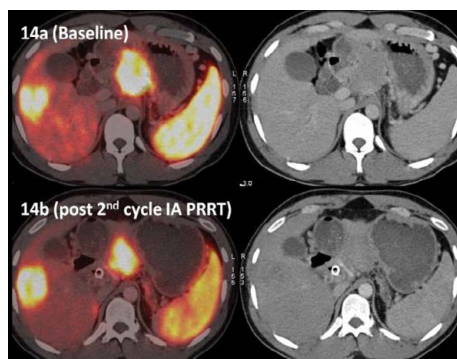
Patient 4, known primary NET of pancreas with liver metastasis, had SSR positive primary growth in the head and uncinate process of pancreas with liver metastasis in segment VI of liver showed mild decrease in the size of the pancreatic lesion with significant fall in the SUVmax (71 to 32.5) after 2 cycles of PRRT.
